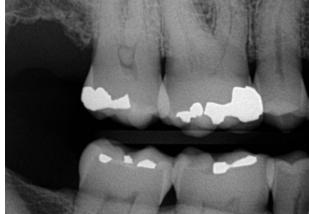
Bitewing Radiographs of the Right Posterior Teeth taken 3 months before pain occurred
